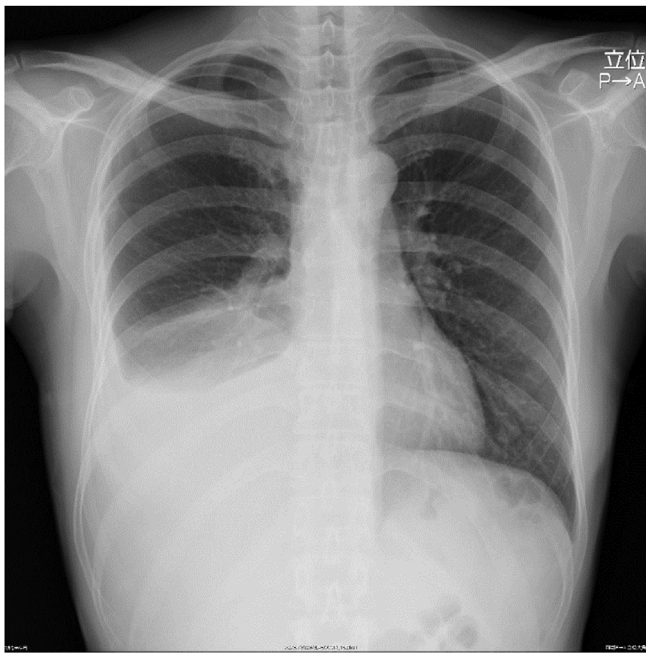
Radiological findings on admission. Chest radiograph revealing right pleural effusion.
